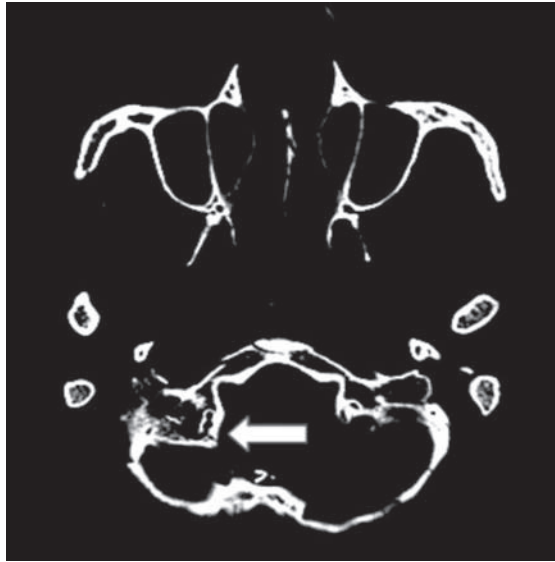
CT scan showing fracture of the basiocciput in the region of the right hypoglossal canal (arrow)
